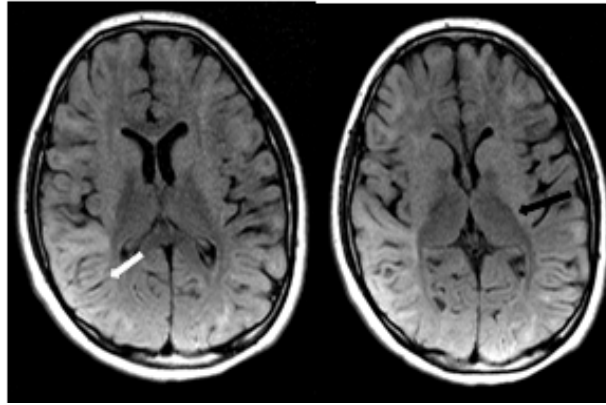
12years old girl (younger sibling) brain Axial FLAIR MR image: Hyperintense diffuse brain subcortical white matter lesions (white arrow). The deep white matter of the bilateral thalamus and periventricular region is preserved (black arrow)
